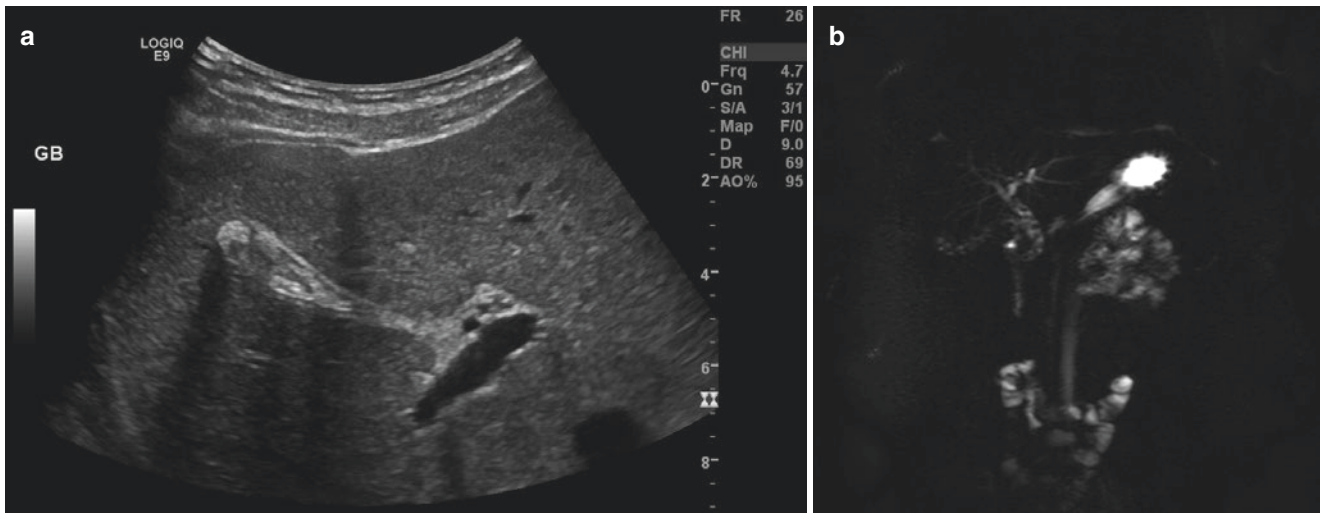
(a) Abdominal ultrasound reveals multiple gall stones in the gall bladder and common bile duct which are also seen on the MRCP (b)
